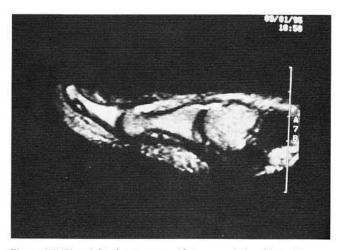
T2-weighted sequence with increased signal intensity.
